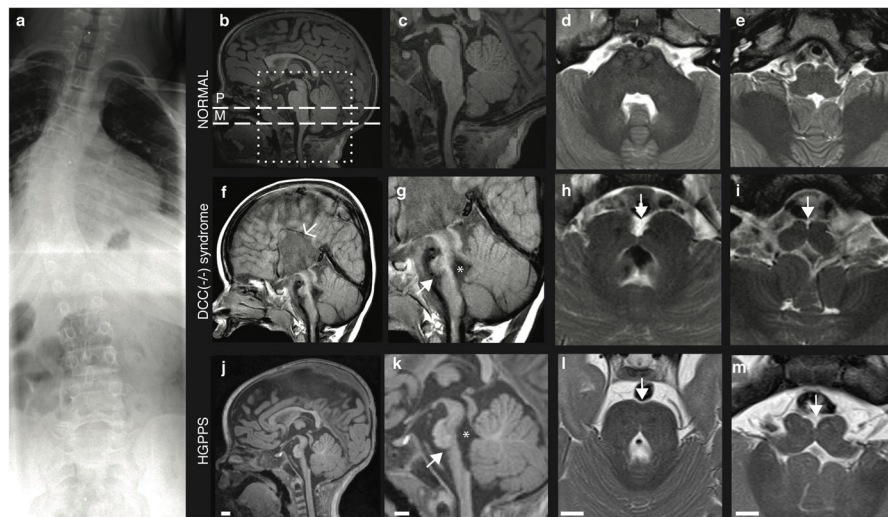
Radiographic features of the *DCC* (-/-) syndrome
